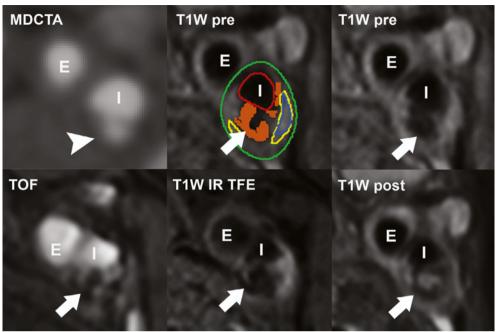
Example of how misinterpretation of the MRI have led to overestimation of calcifications on MRI compared to MDCTA. Corresponding MDCTA and MR images of a patient in which the mismatch between MDCTA and MRI (MDCTA calcification absent; MRI calcification present) can be explained by misinterpretation of the hypointensity on MRI: hypointensity is scored as calcification on MRI, whereas a plaque ulceration was identified on MDCTA (arrow head). E external carotid artery; I internal carotid artery; arrow calcification.
